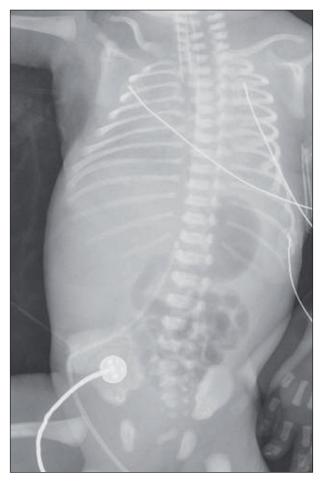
Abdominal radiograph on the 1<sup>st</sup> day of life.
